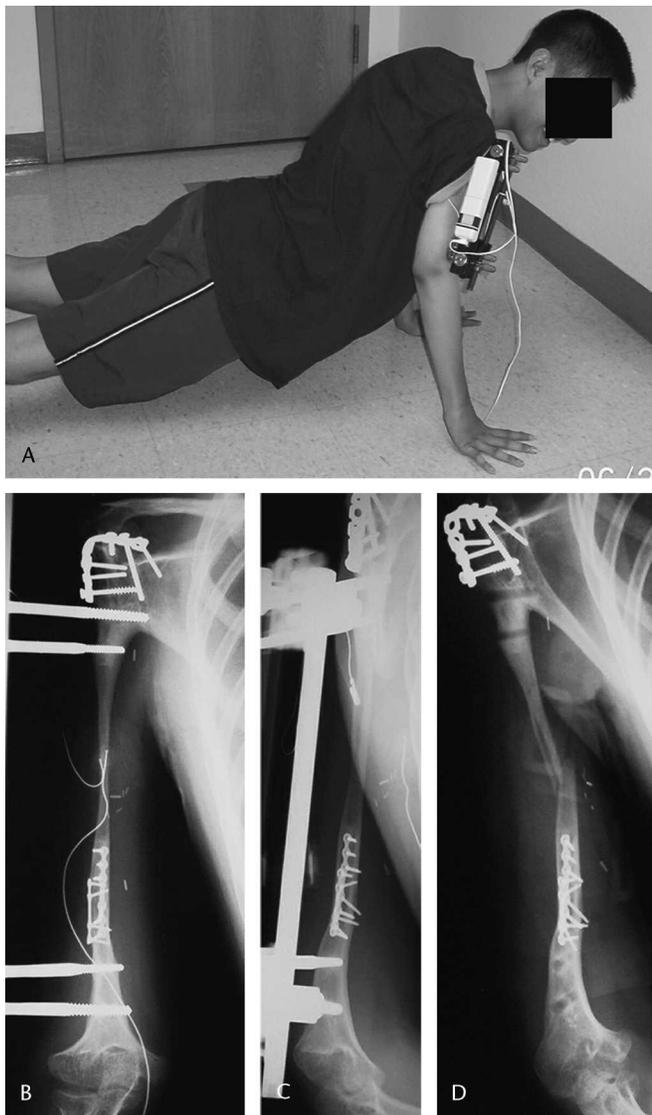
(A) A photograph shows the patient doing weight-bearing exercises during the consolidation phase. (B) Anteroposterior and (C) lateral radiographs show the patient's right humerus before removing the external fixator. (D) A radiograph of the patient's right humerus after frame removal shows a fracture through midportion of the regenerate.
